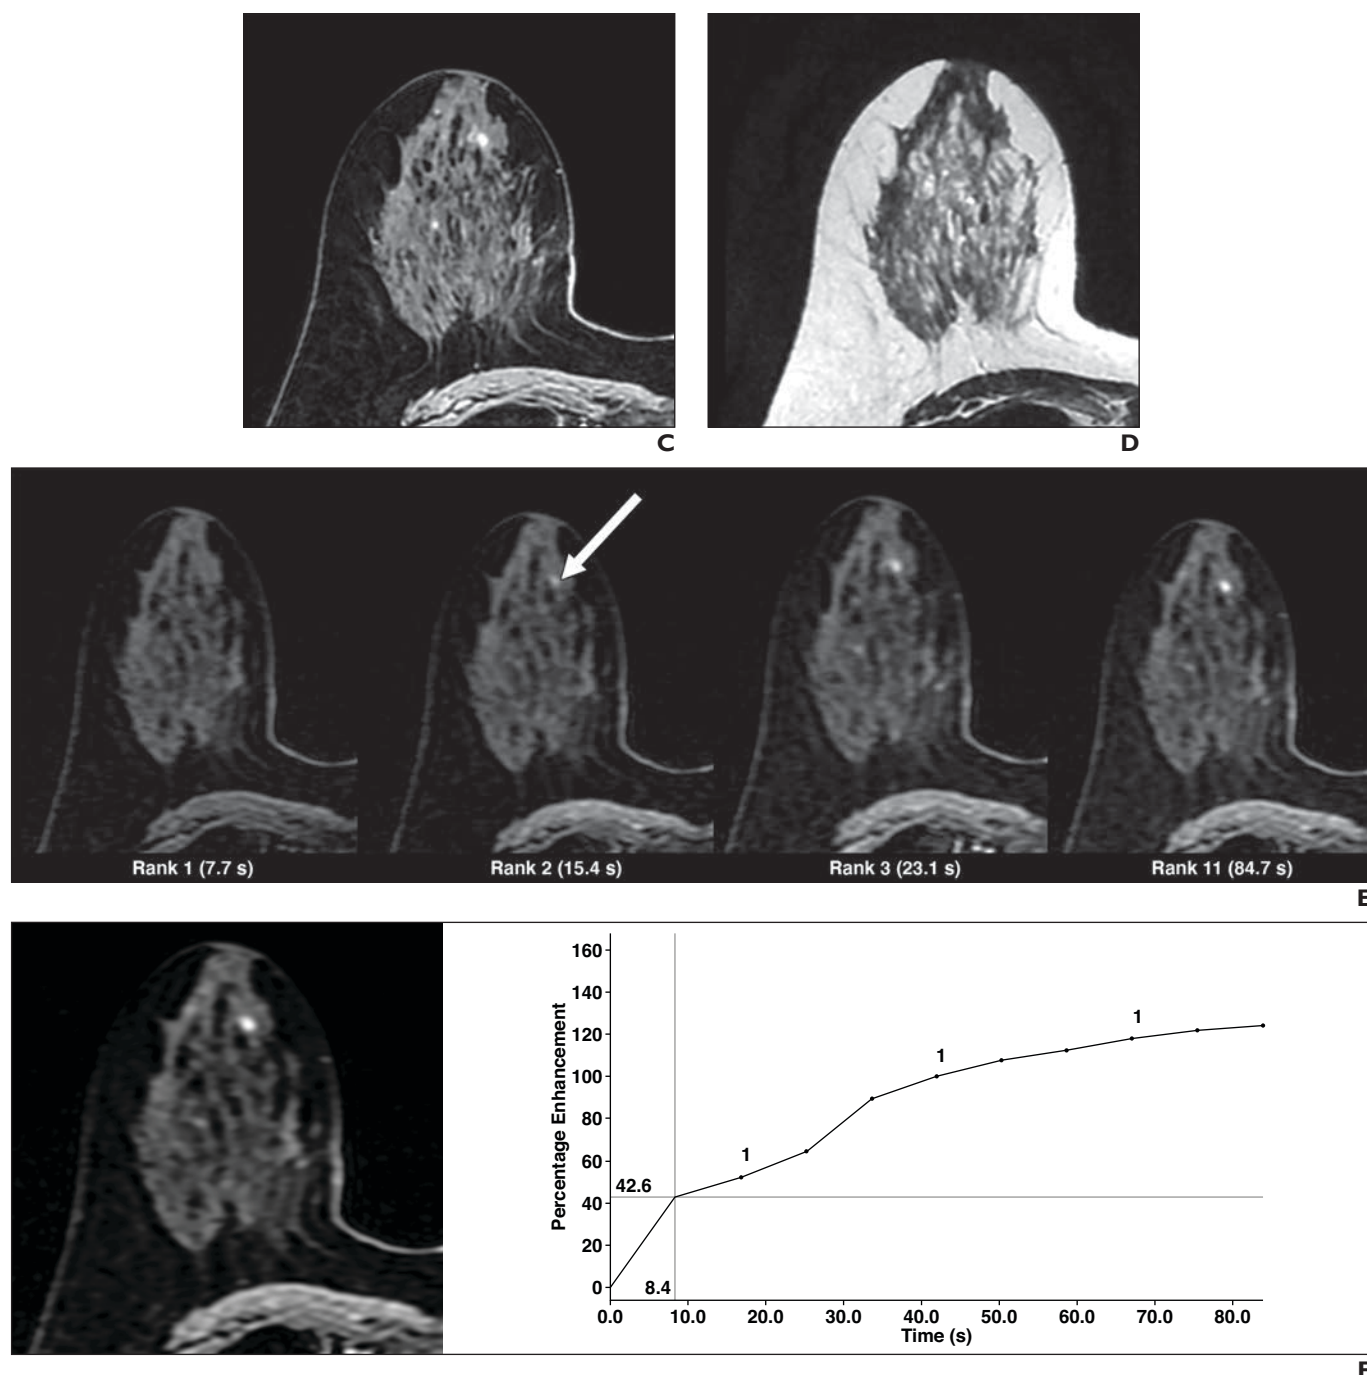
(continued)—Steps for analyzing breast MRI including ultrafast sequence. 70-year-old woman who underwent breast MRI for staging of mass (lobular carcinoma of superior and medial quadrant of right breast). She had undergone tumorectomy for contralateral breast carcinoma 4 years before. C and D. In second step, reader must determine if lesion displays suspicious morphologic features (e.g., irregular shape, irregular or spiculated margins). Morphologic features are better analyzed on conventional contrast-enhanced high-spatial-resolution T1- (C) or T2-weighted (D) MRI. This lesion is round and margins are circumscribed, which means that morphologic features are not suspicious. Lesion would be classified BI-RADS category 3 or 4 depending on enhancement characteristics. E–G. Third step consists of kinetic analysis that is required for correct BI-RADS classification of lesion presenting benign morphologic features. Ultrafast sequence reveals very early lesion enhancement (depending on temporal resolution chosen). This lesion (*arrow*, E) is first visible on rank 2 of ultrafast sequence (E), which is DISCO sequence (GE Healthcare; techniques using view-sharing and undersampling k-space periphery) with temporal resolution of 7.7 s for each rank, which means enhancement within first 15 s after contrast material injection. Reader may draw ROI within lesion for ultrafast sequence (F) or conventional DCE-MR sequence (G). Early enhancement of lesion on ultrafast sequence is suspicious. Lesion presents conventional enhancement according to time–signal intensity curve type 2. Biopsy showed it to be invasive ductal carcinoma (grade 2).
